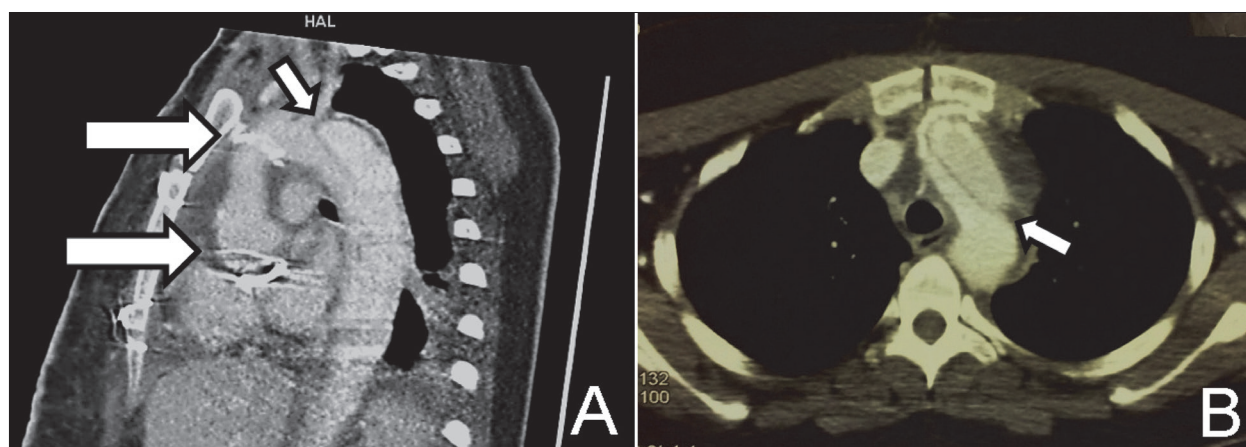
Postoperative computed tomography angiography of the aorta (A – sagittal plane and B – transversal plane): proximal and distal anastomosis of the graft with the prosthetic valve (large arrows) and intimal flap in the aortic arch (small arrows)
